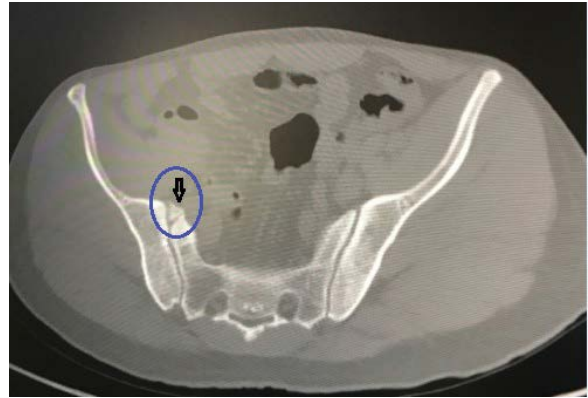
Axial computed tomography section image of the unilateral ossification centre at the S2 vertebral level in the anterior section of the joint space in a 44-year-old man patient.
